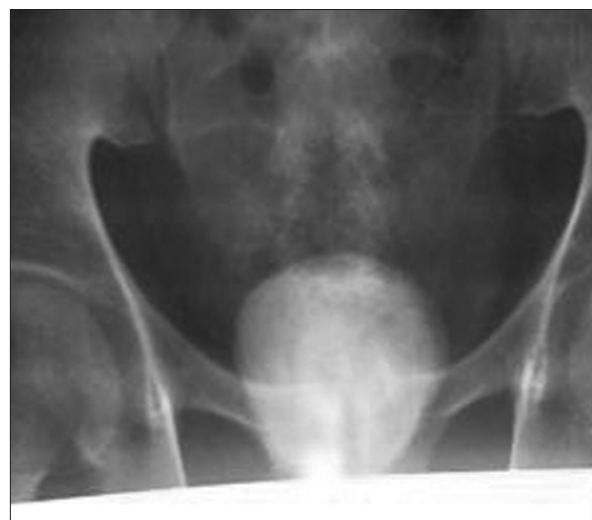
Plain pelvic X-ray showing prostatic urethral calculus
